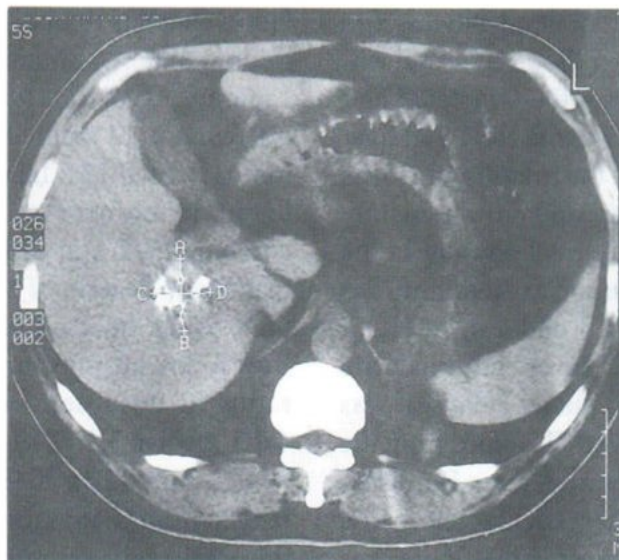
Six months after the first injection of Lipiodol I*131, the computed tomography study of the abdomen showed the HCC was smaller than 2x3 cm.
